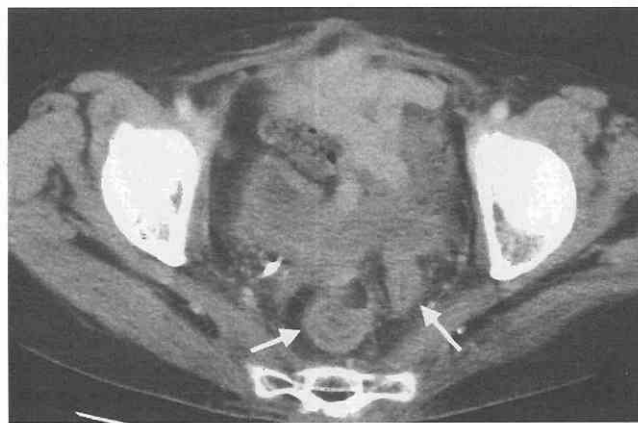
Radiation colitis after radiation therapy for cervical cancer. CT scan shows bowel wall thickening (arrows) of the rectum and sigmoid colon with the "target sign."
